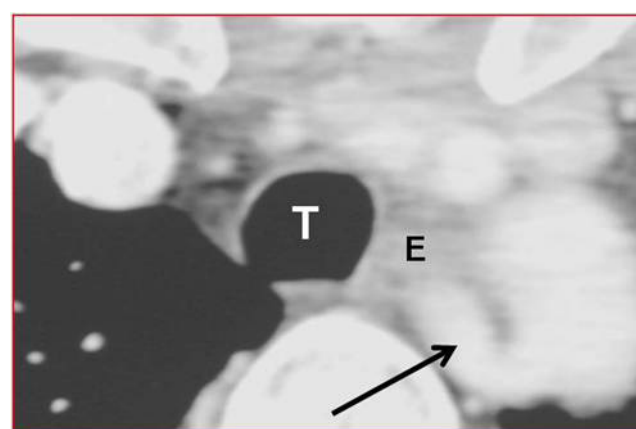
Axial CT scan caudal to 2a showing the origin of the aberrant right subclavian artery from the posterior wall of the aortic arch. There was no aneurismal dilatation of this vessel. (T: Trachea, E: Esophagus)
